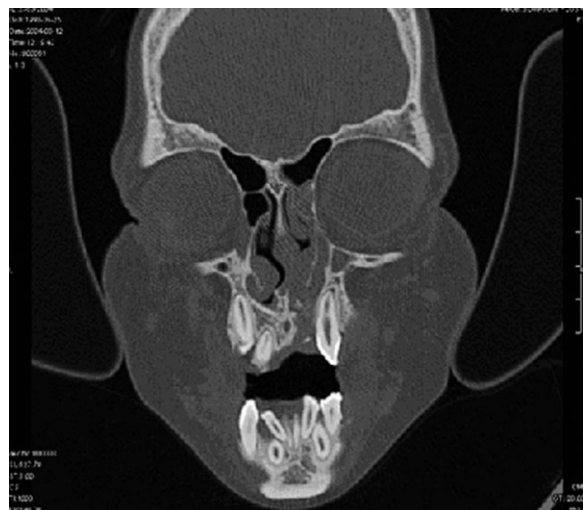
CT examination – fistulization of the hard palate.
